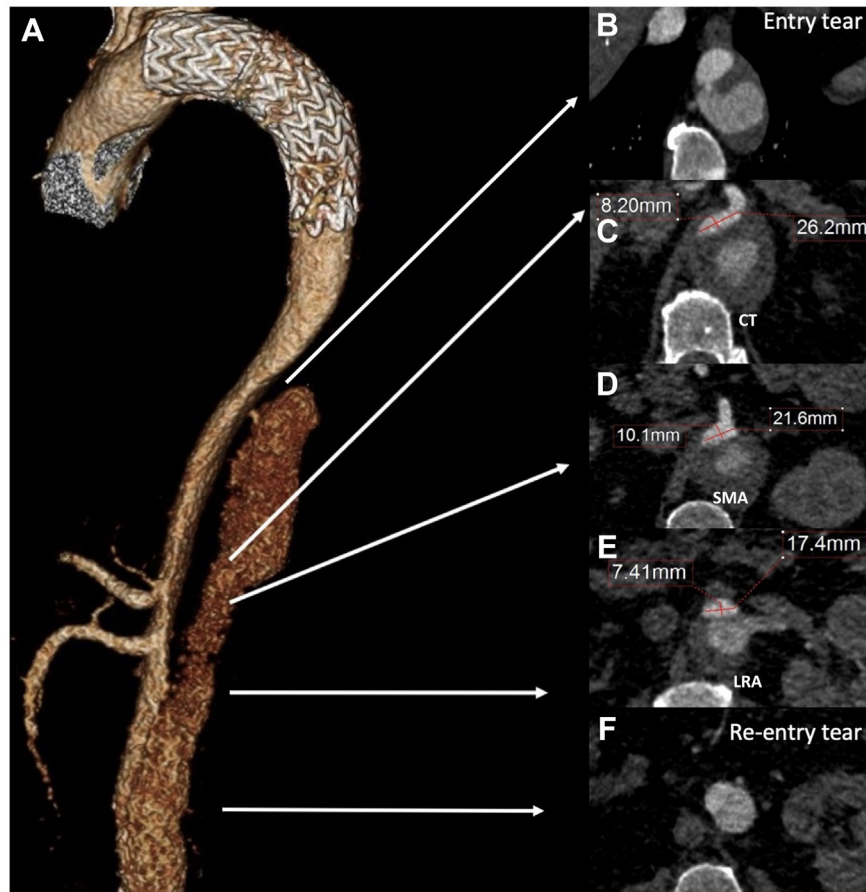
(A) Three-dimensional computed tomography angiogram (CTA) reconstruction in lateral view, showing the narrow paravisceral true lumen; dotted arrows indicate the proximal and distal reentry tears. (B) Axial image of the dissected aorta at the level of proximal reentry tear (C) at the level of celiac trunk (CT) with a compressed true lumen diameter of 8.2 mm. (D) Axial image of the dissected aorta at the level of the superior mesenteric artery with a true lumen diameter of 10.1 mm. (E) Axial image of the dissected aorta at the level of the left renal artery with a true lumen diameter of 7.4 mm. (Measurements with dotted underline, are based on the Society for Vascular Surgery reporting standards⁴). (F) Axial image of the dissected infrarenal aorta at the level of distal reentry tear. SMA, Superior mesenteric artery; LRA, left renal artery; CT, celiac trunk.
